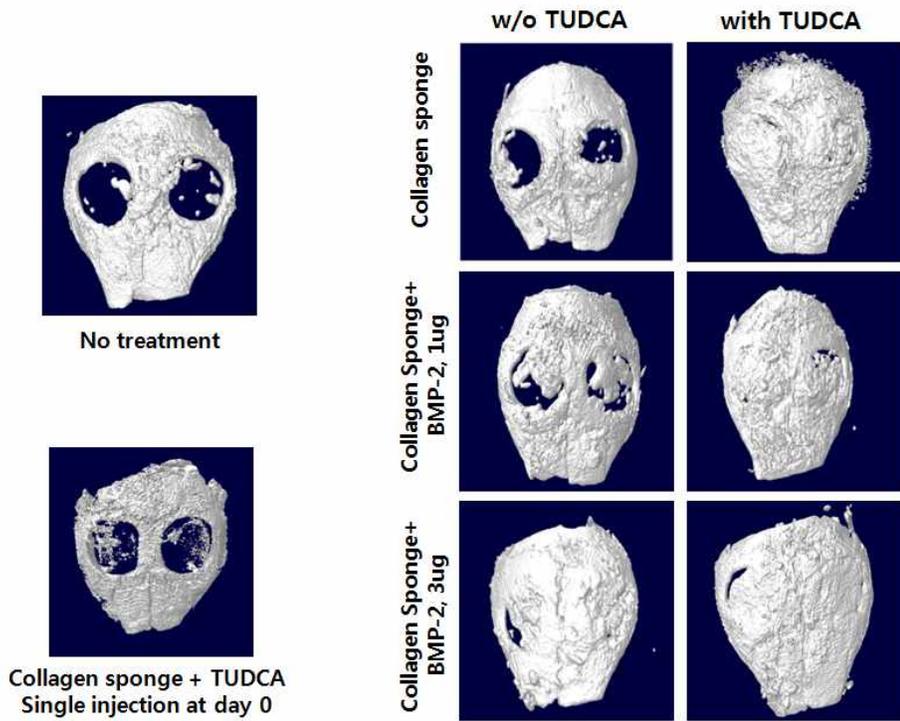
Micro computed tomography ( $\mu$ CT) image.
